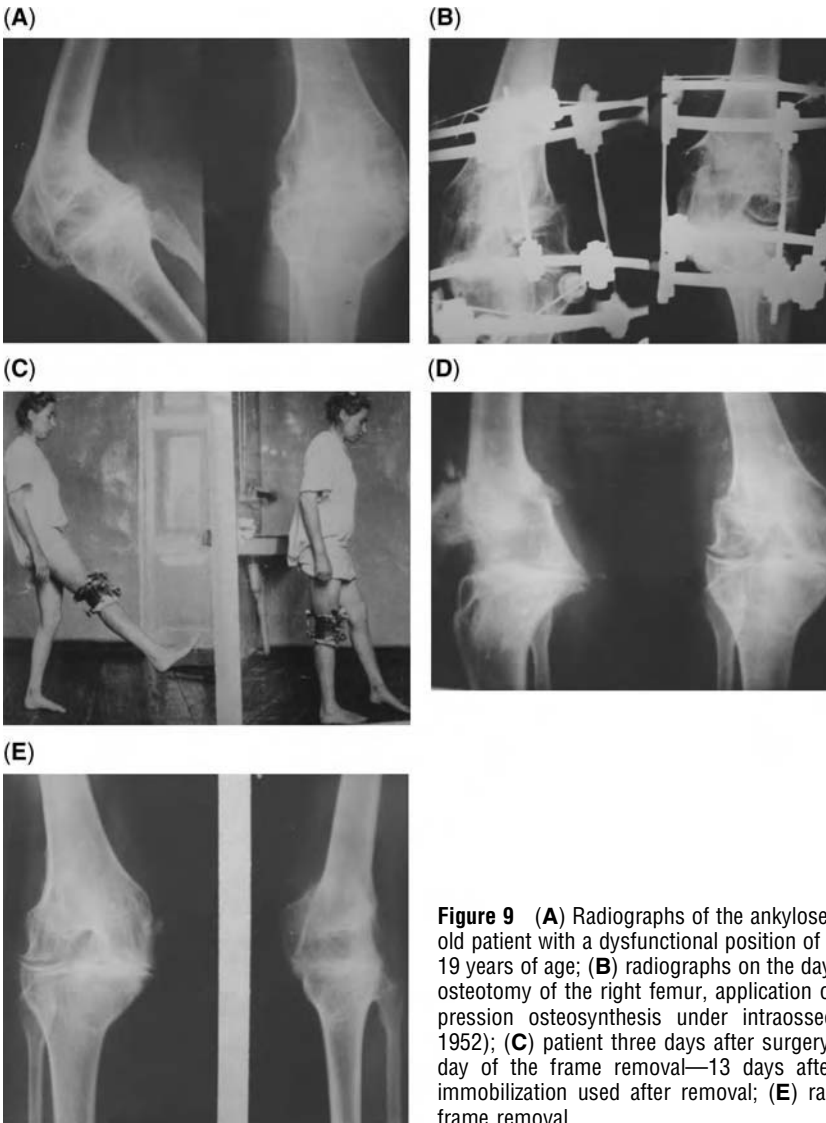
(A) Radiographs of the ankylosed knee joint of a 41-year-old patient with a dysfunctional position of the knee after infection at 19 years of age; (B) radiographs on the day of hinged supracondylar osteotomy of the right femur, application of the apparatus for compression osteosynthesis under intraosseous anesthesia (July 7, 1952); (C) patient three days after surgery; (D) radiographs on the day of the frame removal—13 days after surgery, no additional immobilization used after removal; (E) radiographs one year after frame removal.
